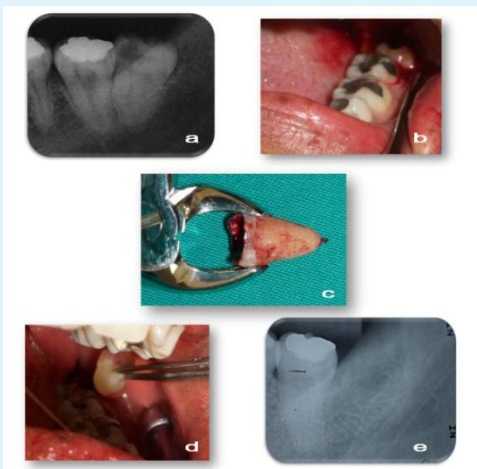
a) Periapical radiography of wisdom tooth.
